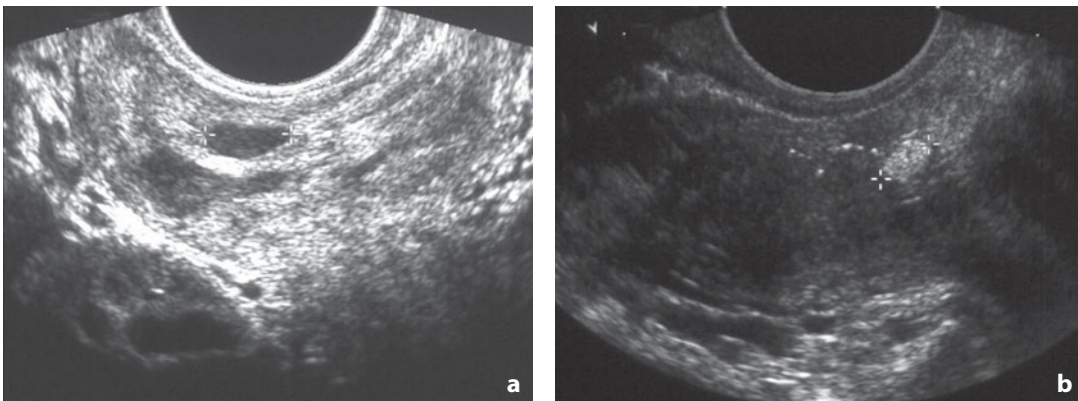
Transrectal ultrasonography. Endometriosis of the rectovaginal septum. Hypoechoic (a) and hyperechoic (b) solid endometrial nodule can be identified in the rectovaginal septum (crosses)
